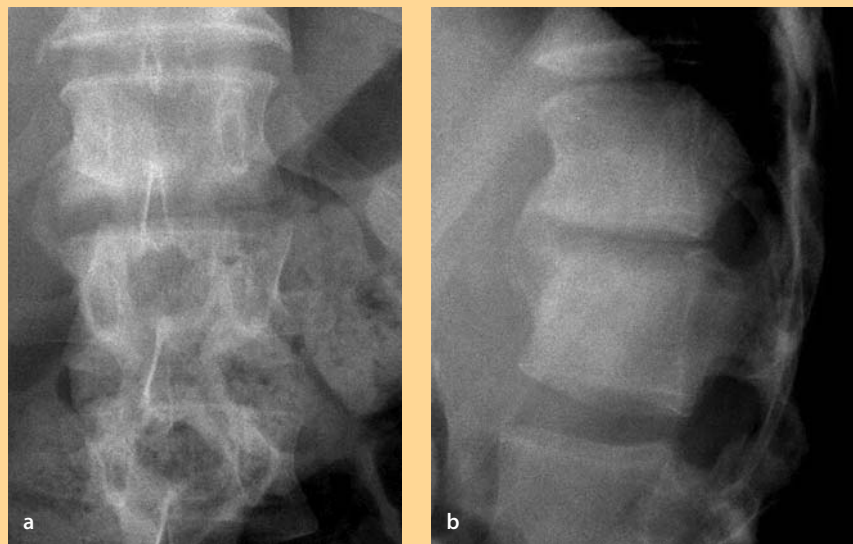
Radiographic findings in spinal infection
